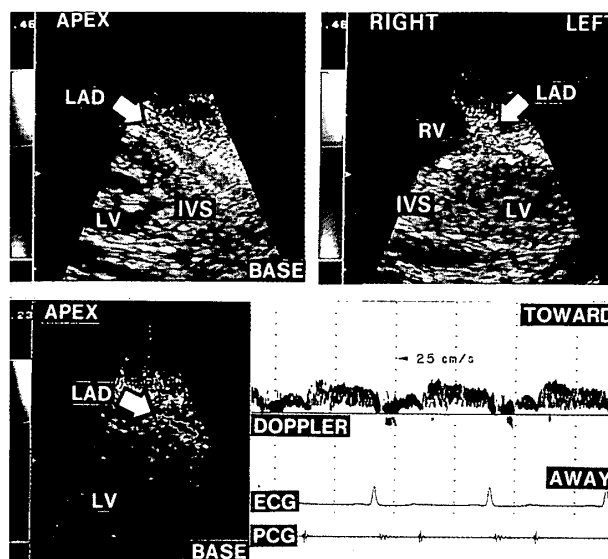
Doppler flow signal in the left anterior descending artery. The long-axis echocardiographic section (left upper panel) and short-axis section (right upper panel). Placement of sample volume in the distal LAD (left lower panel) for the measurements coronary flow velocity in the LAD (right lower panel) in pulse Doppler flowmetry.
